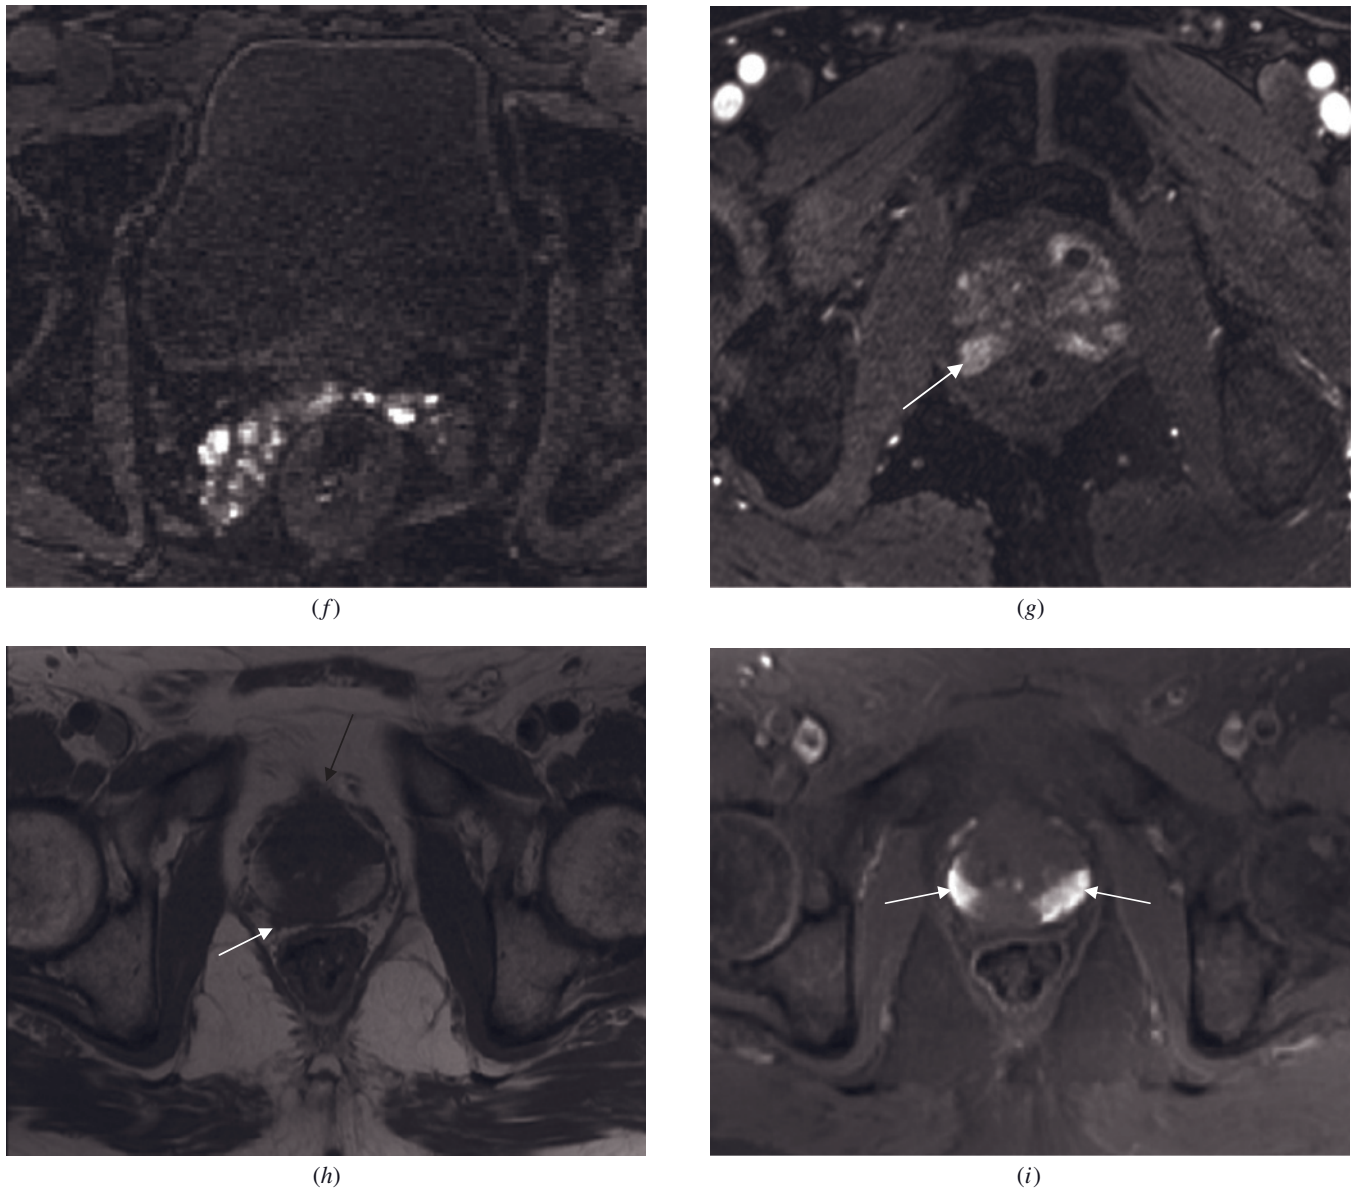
(Continued) demonstrate low signal on T2 weighted image (*e*) and high signal on T1-weighted image (*f*) due to blood products secondary to the biopsy procedure. The prostate gland including the tumor (arrow) shows heterogeneous moderate enhancement on postgadolinium image (*g*). Postbiopsy hemorrhage within the prostate. Transverse high-resolution T2-weighted fast spin-echo (*h*) and transverse T1-weighted fat-suppressed arterial-phase 3D-GE (*i*) images demonstrate postbiopsy hemorrhage in another patient with prostate carcinoma with extracapsular extension. The tumor, which shows markedly low signal on T2-weighted image, invades the fibromuscular stroma anteriorly (black arrow, *h*) and the capsule posterolaterally on the right side (white arrow, *h*). Areas of markedly increased signal (arrows, *i*) on T1-weighted image demonstrate moderately high signal on T2-weighted image (*h*), and these findings are consistent with blood products secondary to the biopsy procedure.
